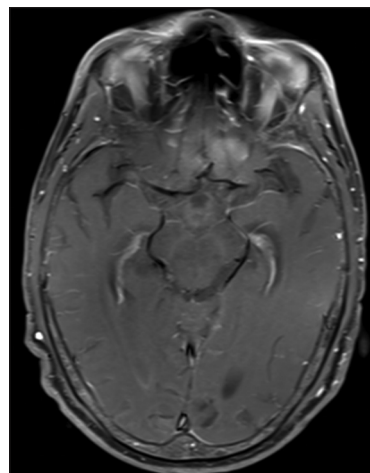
Axial contrast enhanced magnetic resonance imaging section at the level of aqueduct in midbrain
